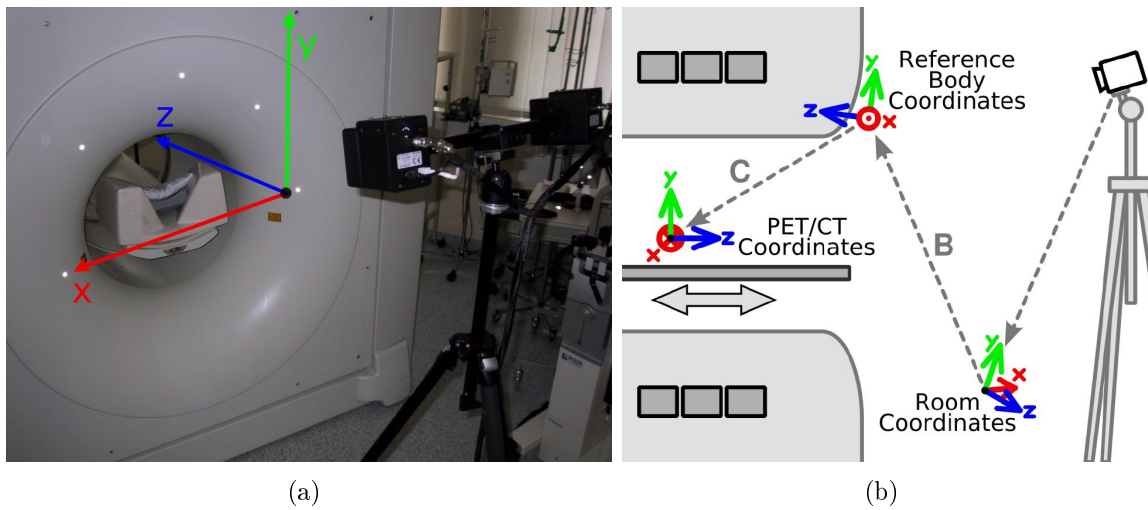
Set of flat markers attached to the PET/CT gantry used as reference body (a) and spatial transformations used to compute the motion in the PET/CT coordinate system (b). Image reproduced from [242].
